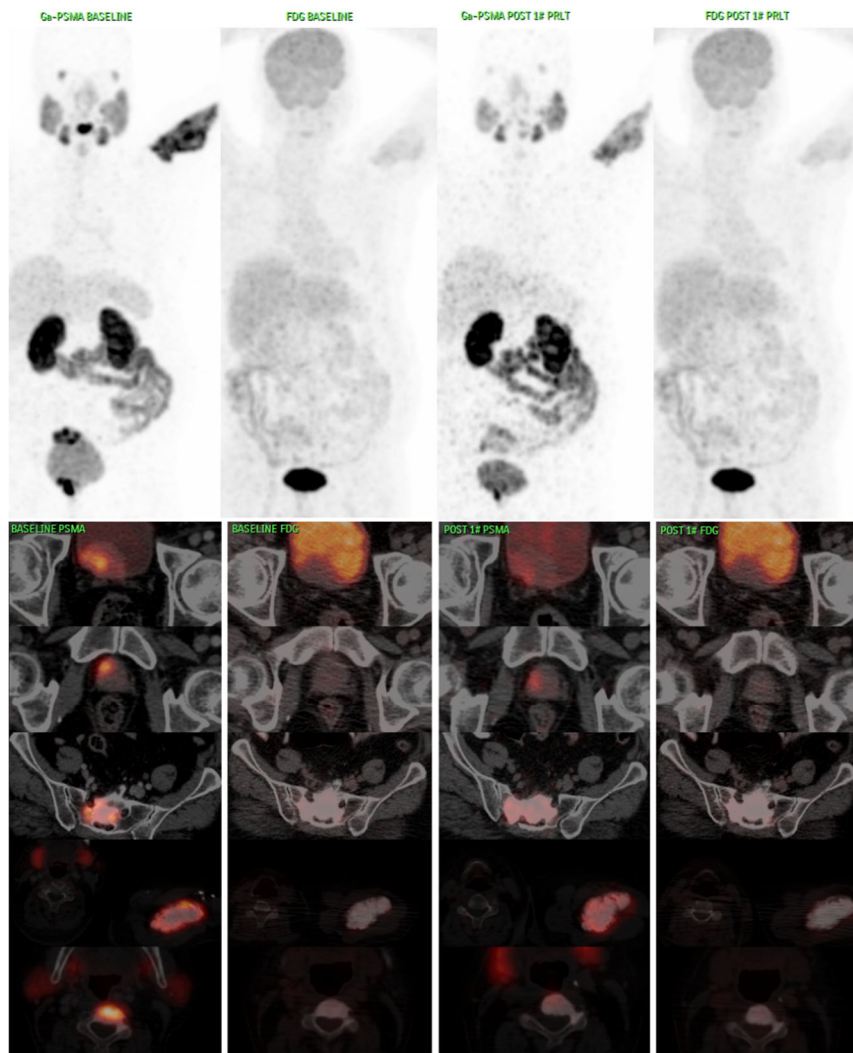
Comparative analysis of PSMA and FDG PET CT scans at baseline (left sided 2 panels) and post  $^{177}\text{Lu}$ -PSMA PRLT (right sided 2 panels) of Case I.
